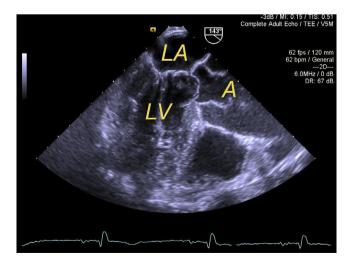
Echocardiographic depiction of accessory mitral valve tissue (A, ascending aorta; LA, left atrium; LV, left ventricle).
